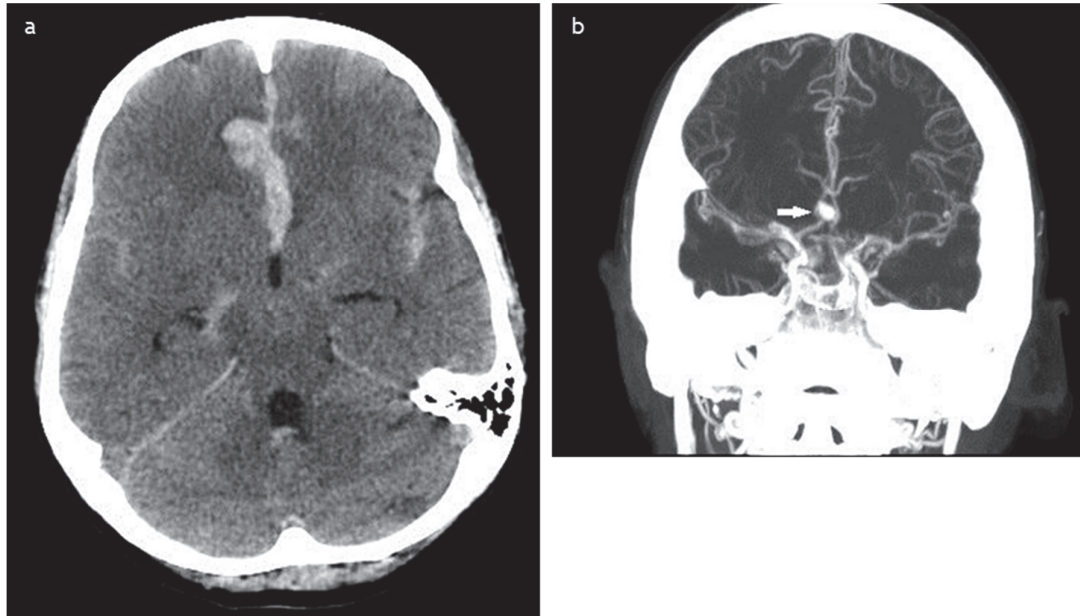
a. Cerebral CT showing subarachnoid hemorrhage. b. Cerebral CT angiography showing aneurysm of anterior communicating artery (ACoA).
